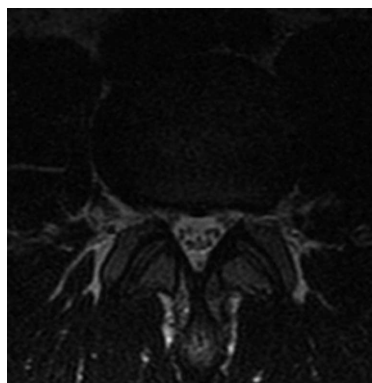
Axial T2-weighted (3516, 115) image of the lumbar spine in a 29-year-old male with congenital lumbar spinal stenosis demonstrates a circumferential disc bulge with a superimposed left foraminal disc protrusion.
